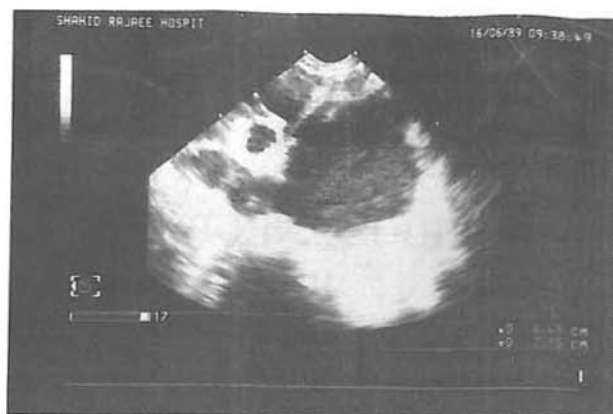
Echocardiogram (short-axis view) depicting aneurysmal mass adjacent to the descending thoracic aorta and left atrium.
